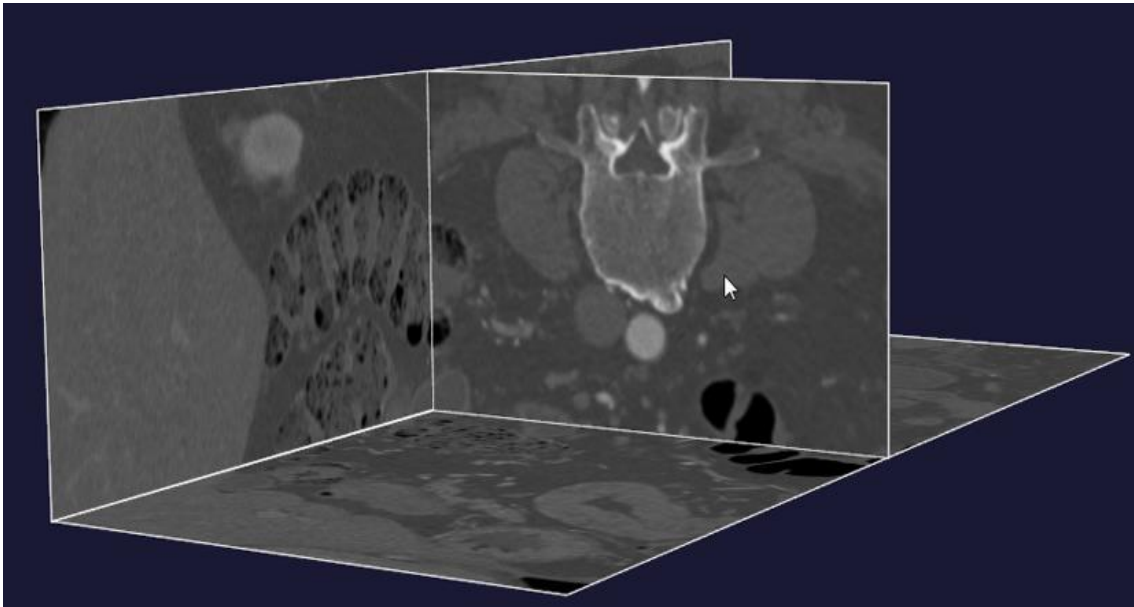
8 The 3D CT dataset of the specific patient
